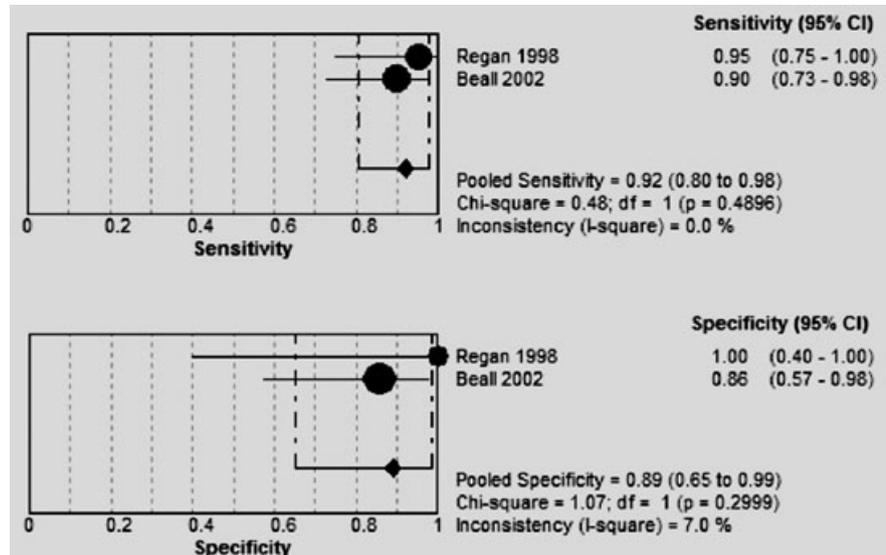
Meta-analysis of studies assessing MRI performance for SBO diagnosis. SBO = small bowel obstruction.
